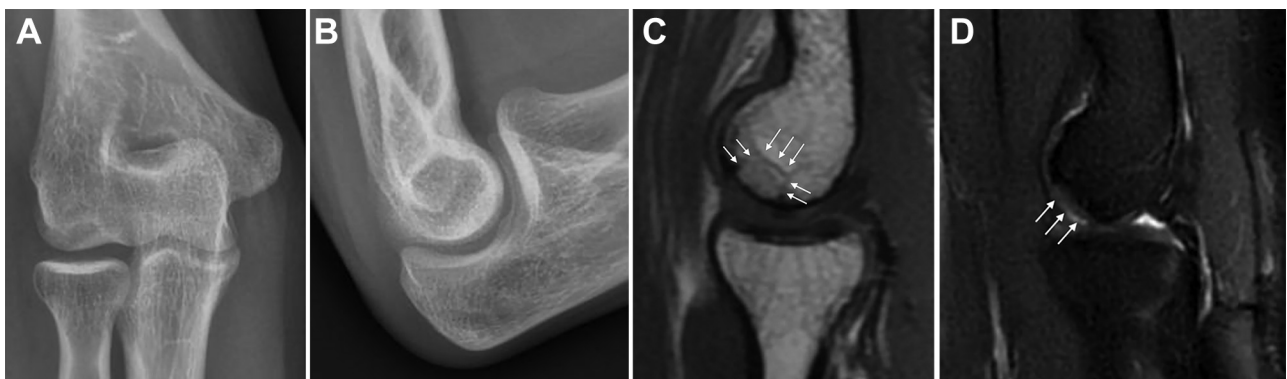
(A) Anteroposterior and (B) lateral radiographs at 47 months postoperatively showing complete incorporation of the graft without lucency or sclerosis around the graft. (C) T1-weighted sagittal MRI scan obtained in the same patient at 47 months postoperatively, demonstrating incorporation of the graft and a faint "scar" (white arrows) outlining the graft. (D) T2-weighted MRI scan of the same elbow demonstrating fully incorporated graft, no stress reaction, and preservation of the cartilage on the graft (white arrows). MRI, magnetic resonance imaging.
